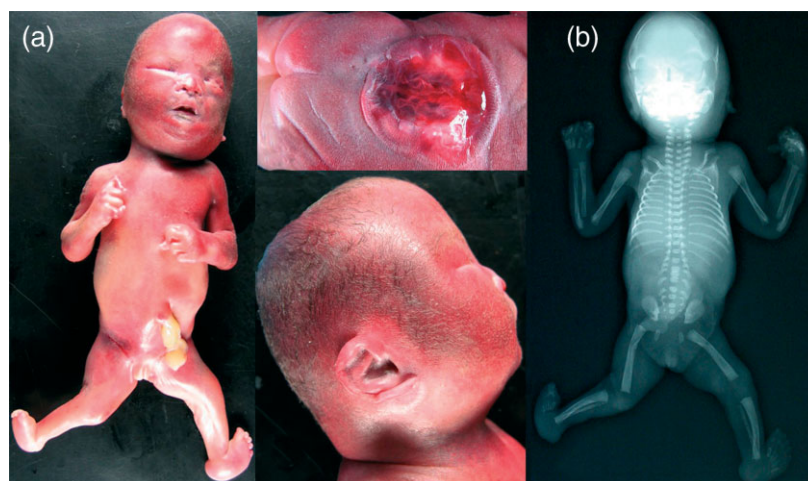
Postmortem examination of the fetus: (a) external aspect of the fetus revealed dysmorphic face with hypertelorism, low-set and malformed ears, short neck, micrognathia, prominent forehead, flat occiput, and flattened face; fingers abnormalities, fifth finger clinodactyly, genu recurvatum, bilateral clubfoot, and large lumbar spina bifida aperta. (b) Radiography of the skull showed complete and bilateral dislocation of the tibia on the femur, unilateral dislocation of the hip joint, deformation of lumbar vertebrae associated with the spina bifida, bilateral clubfoot, and ossification defect of the pubis suggestive of Larsen syndrome
